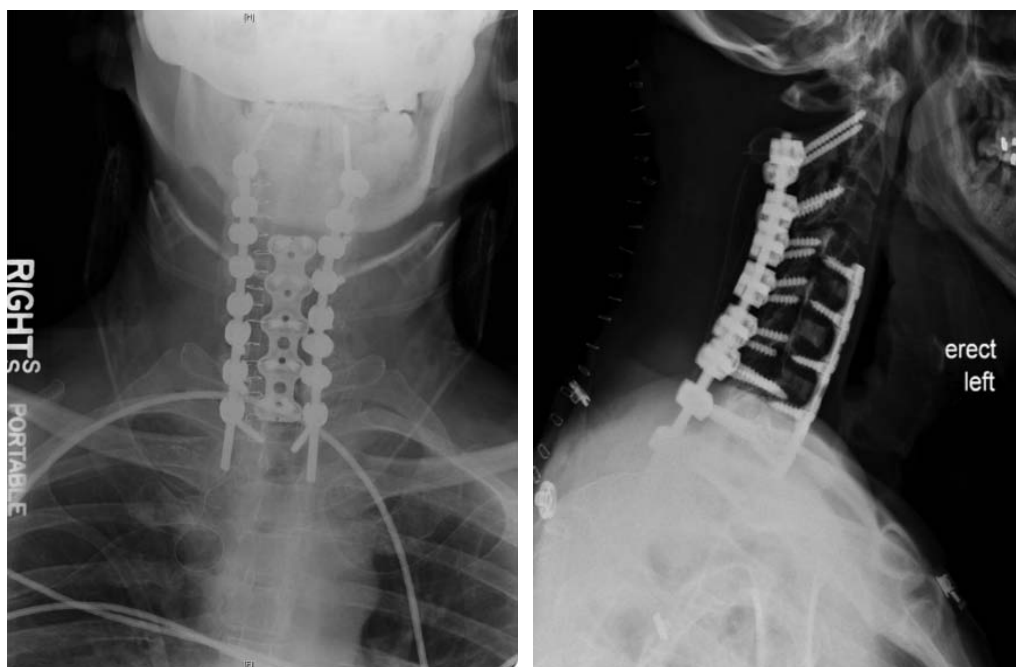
Postoperative antero-posterior and lateral plain radiographs following revision posterior decompression with deformity correction via posterior osteotomies at C2-3 and C3-4 and extension of fusion construct with pedicle screw placement at C2, C7-T2 demonstrating restoration of cervical sagittal alignment.
